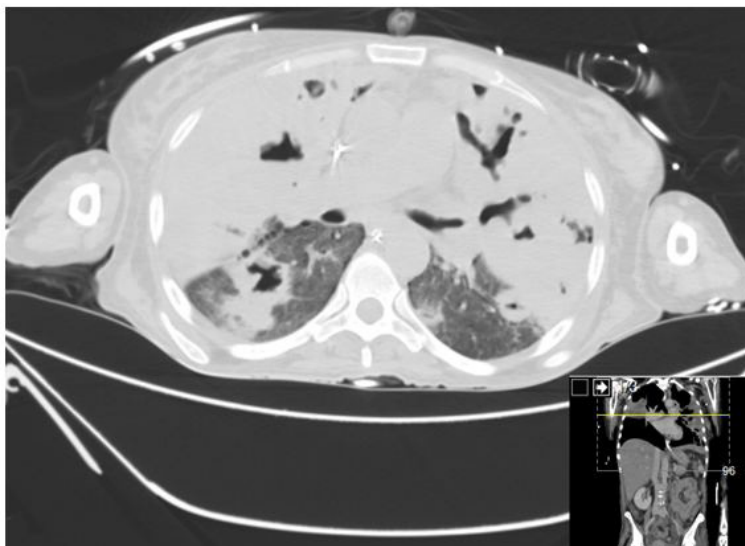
Chest CT showing bilateral and diffuse pulmonary parenchymatous densification, with extensive areas of consolidation that demonstrate cavitation with central disappearance of pulmonary reticulum, findings suggestive of bilateral necrotizing pneumonia with attainment of all lobes.
